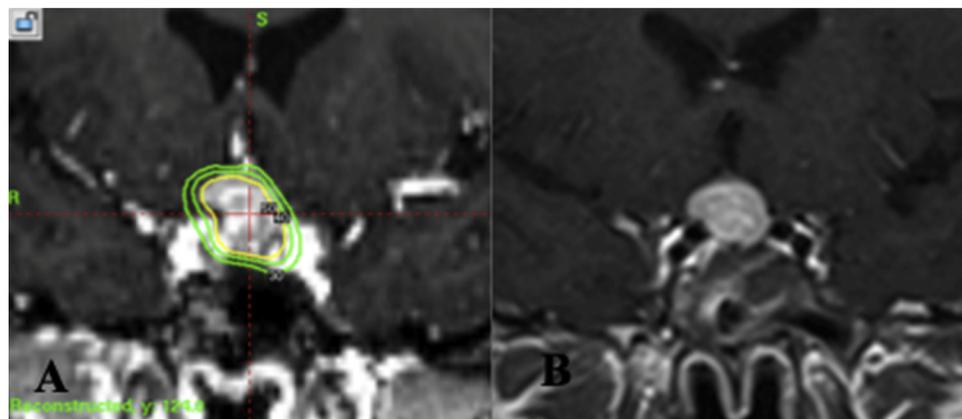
Images obtained in a patient (Case 2) treated with Gamma Knife radiosurgery with 12 Gy prescribed to the 50% isodose line. A. Treatment planning T1-weighted MRI with contrast. B. T1-weighted MRI with contrast images of 3 years after Gamma Knife radiosurgery demonstrating stable tumor volume.
